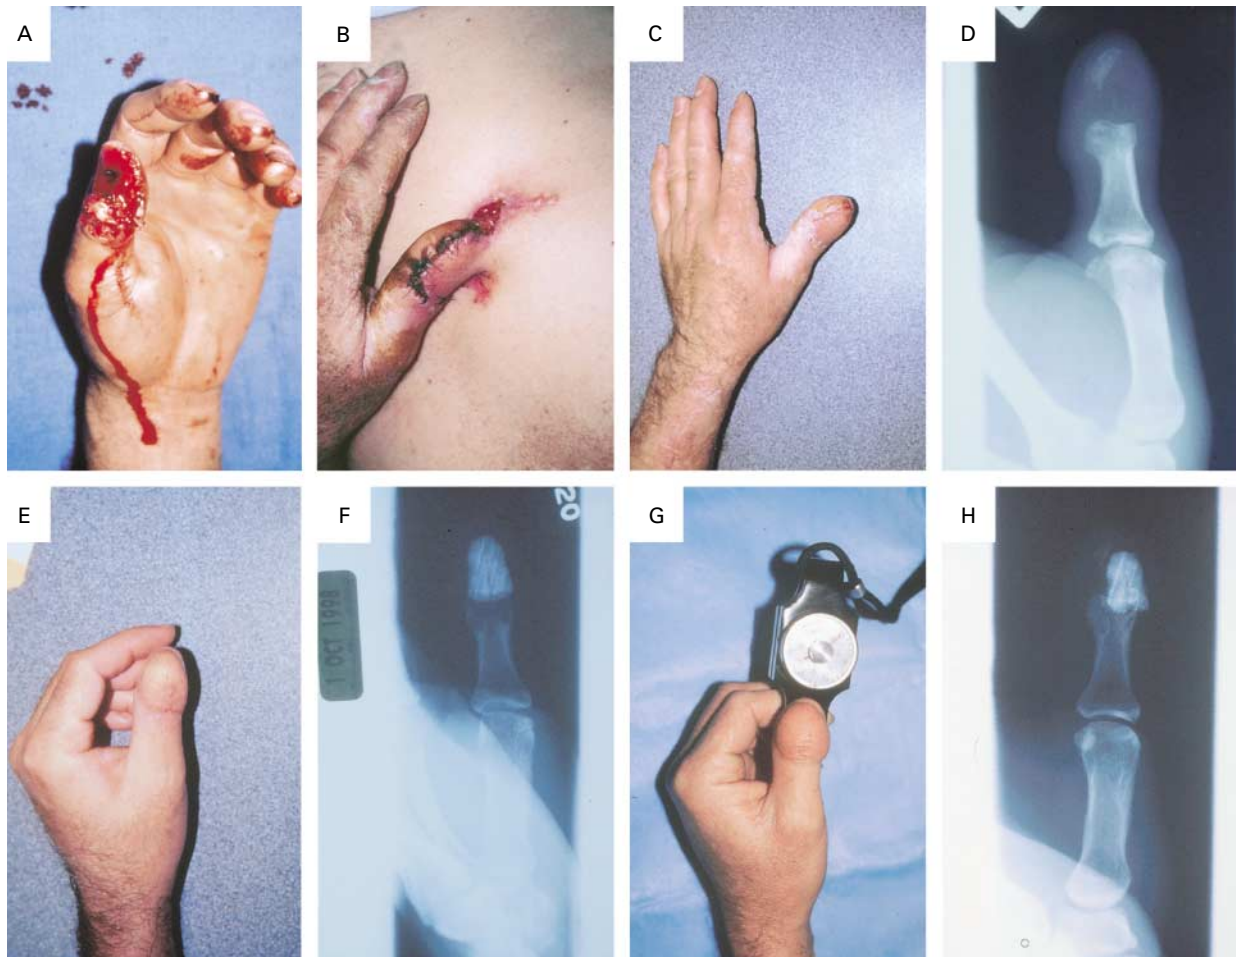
Serial Photographs and Radiographs of the Patient's Thumb after Injury and during Treatment.
